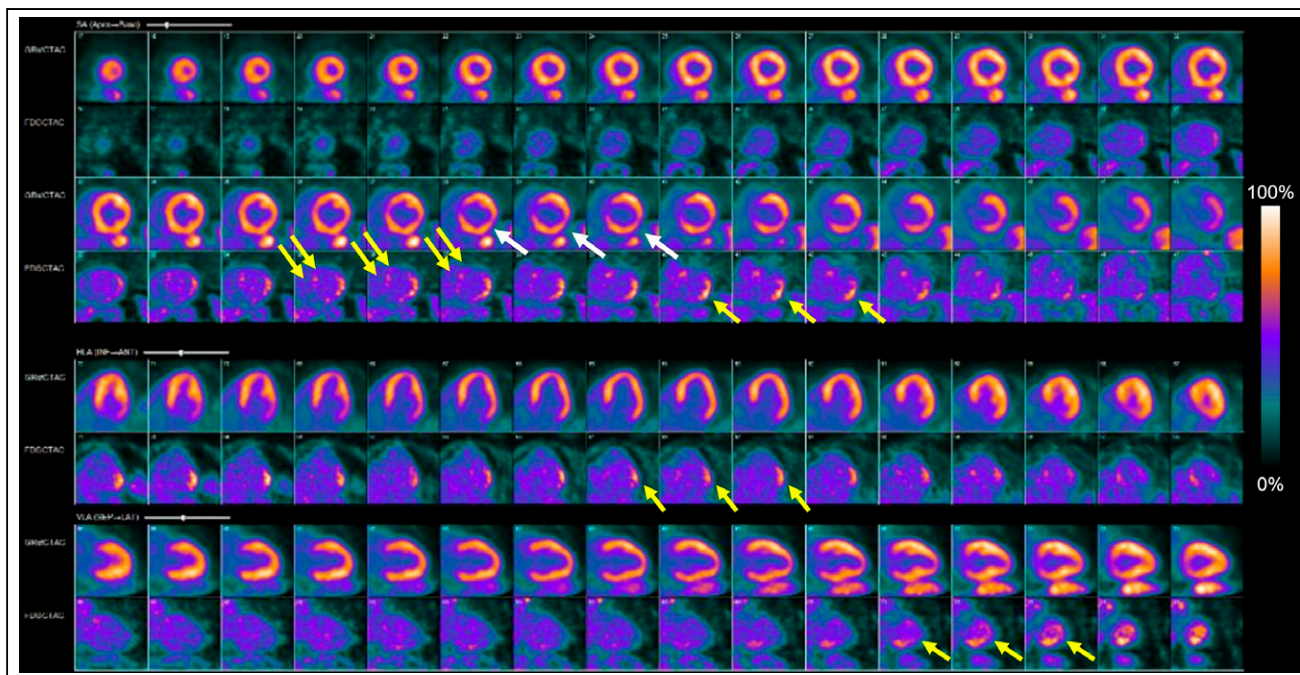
Scan 4 ^{82}Rb -chloride rest perfusion (top rows) and ^{18}F -FDG cardiac metabolism (bottom rows). Rest perfusion images show medium-sized mild defect in basal to mid lateral and inferolateral wall (white arrows). Gated rest LVEF was 31%. ^{18}F -FDG images show diffusely suppressed myocardial uptake, indicating adequate dietary preparation. Medium-sized area of increased ^{18}F -FDG uptake is visualized in basal to mid lateral and inferolateral wall (single yellow arrows) similar to scan 2. New small-sized area of mildly increased ^{18}F -FDG uptake is visualized in basal anteroseptal wall (double yellow arrows).
